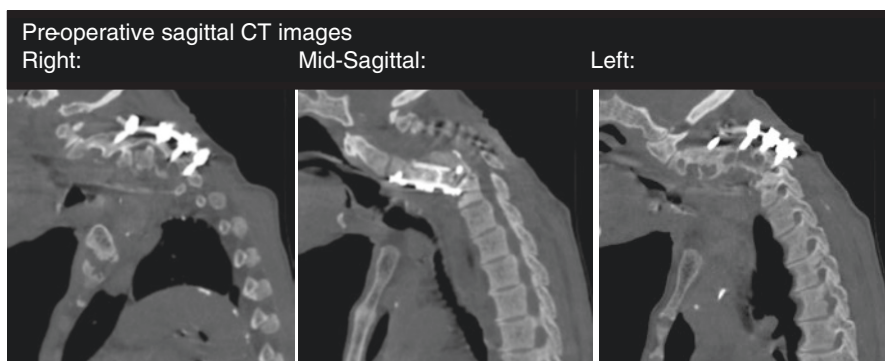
Preoperative sagittal CT images demonstrate distal junctional kyphosis after a prior C4/C5 corpectomy with C3-C7 posterior spinal fusion. There is pseudarthrosis and a kyphotic angulation at C7-T1
